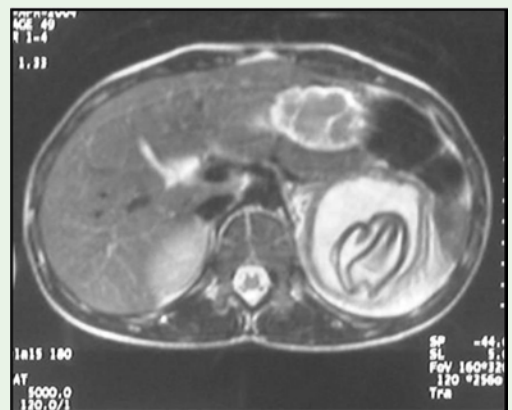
(b): MRI appearance of the left kidney hydatid cyst opened in the urinary tract: longitudinal section.
